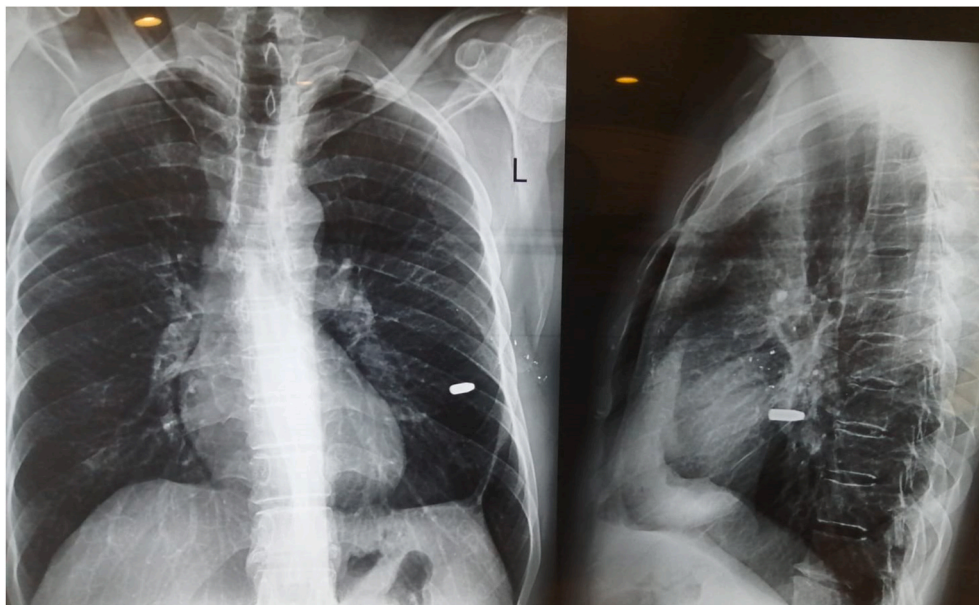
Plain chest x-ray (PA and lateral view) shows metallic foreign body in the left lower zone.
